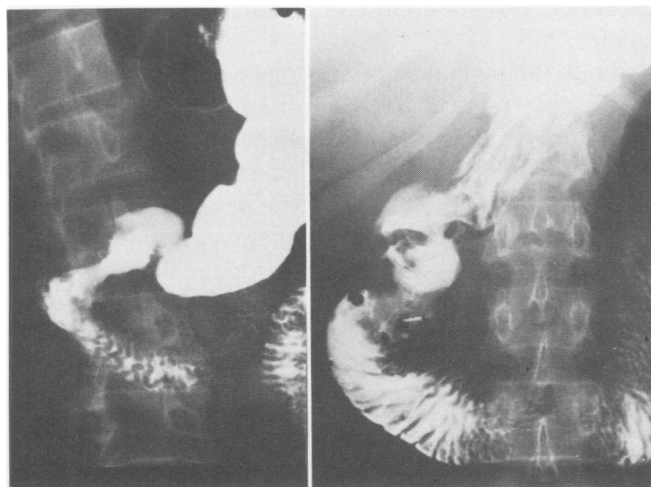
X-ray series showing a multinodular infiltrating duodenal process (Adenocarcinoma; Patient 1 in Table 1).
